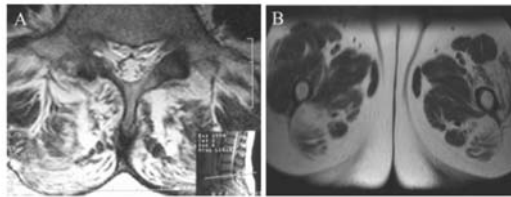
Axial lumbar spine MRI showed T2 hyperintensity in bilateral paraspinal muscles consistent with near complete fatty replacement of the muscles (A). Axial MRI of thigh muscles revealed T2 hyperintensity of bilateral vastus lateralis and intermedus muscles (B), indicating a generalized myopathic process.
